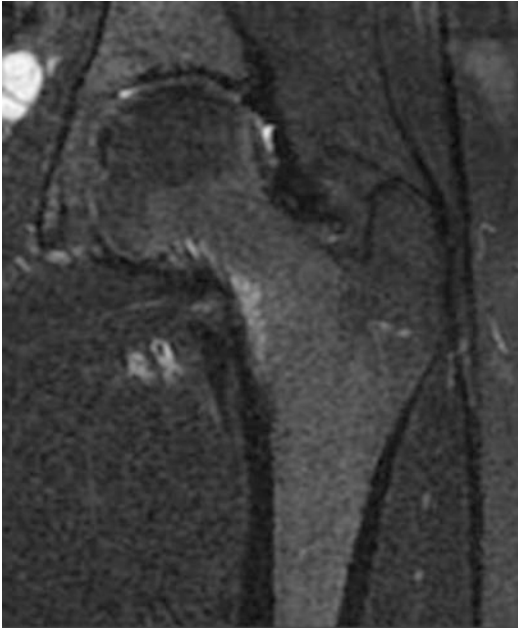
Early detection of medial femoral neck stress reaction with the use of coronal STIR MRI with increased signal over the compression side of the femoral neck
